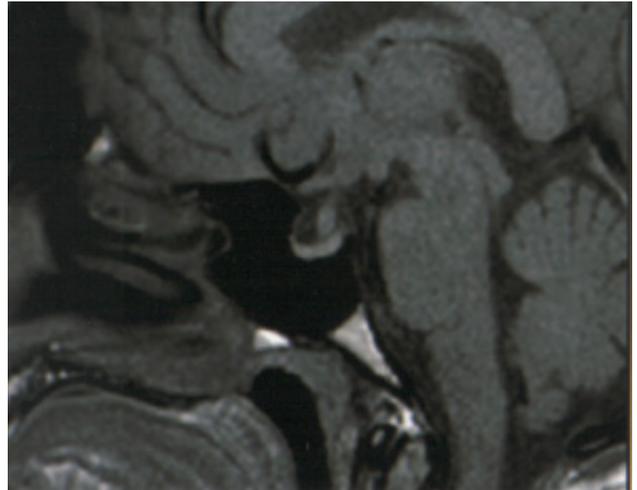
Magnetic resonance T1-weighted image, sagittal section shows thickened infundibulum with loss of posterior pituitary hyperintensity.
